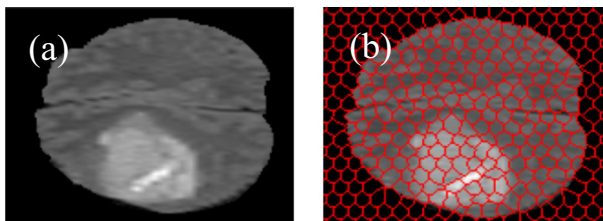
a An original MR image and b the corresponding SPs
